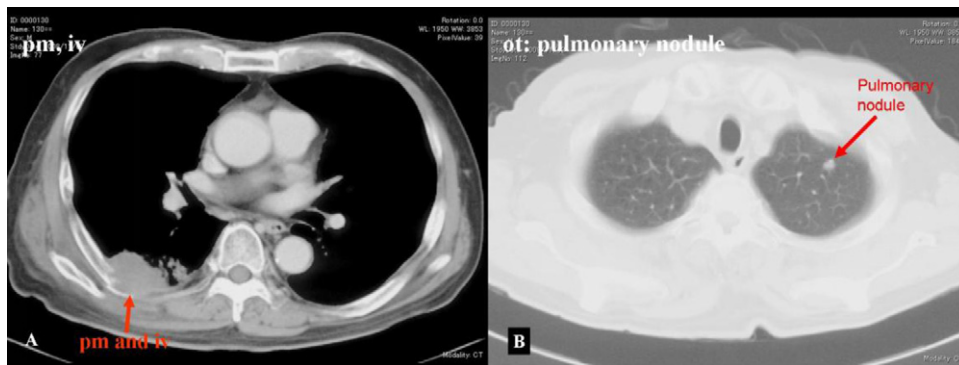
A 68-year-old man with localized sarcomatoid MPM. CT scan demonstrates a right-sided pleural mass invasion (“iv”) to the chest wall destroying rib structure (arrow) (A). There is a pulmonary nodule on the left lung (B). This case was agreed as MPM of moderate probability Grade 3 at advanced severity. The different diagnosis is firstly sarcoma and secondly possible metastasis from other cancer.
